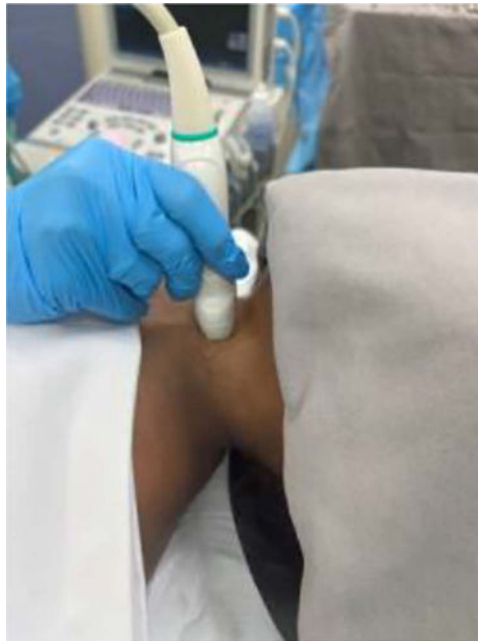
An airway ultrasound examination in the transverse position. The linear probe is positioned over the extended neck, aligned at the top of the thyroid cartilage (figure courtesy of Vinícius Quintao).
